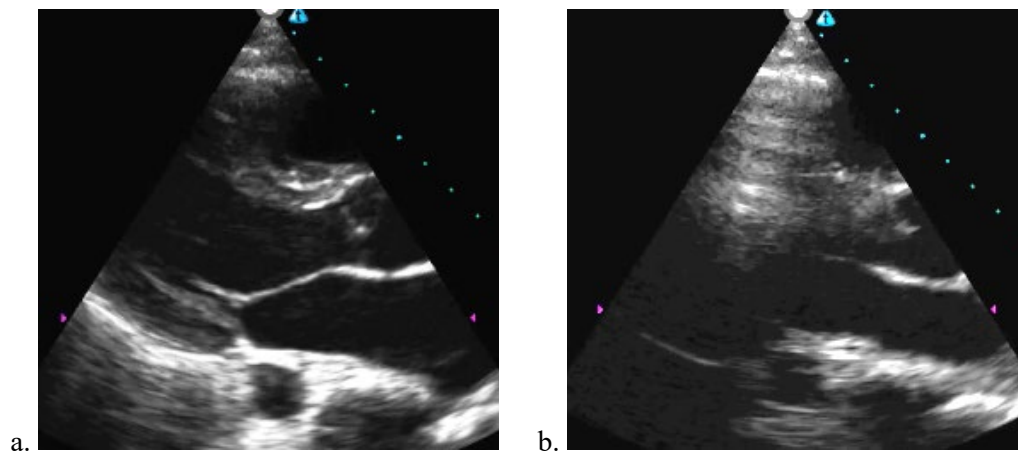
Echocardiographic Image without Reflection Artifact from Lung Encroachment during Exhalation
